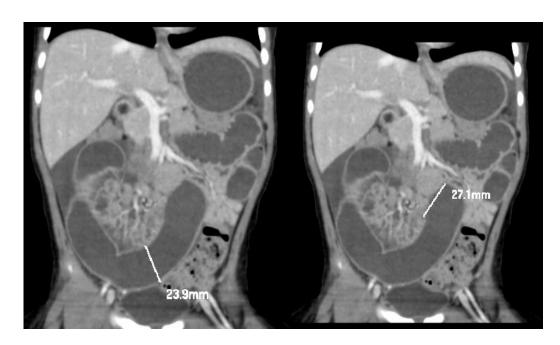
Abdominal CT scan without contrast sagittal section shows intestinal dilatation with a diameter of 23.9 - 27.1 mm (white line).
